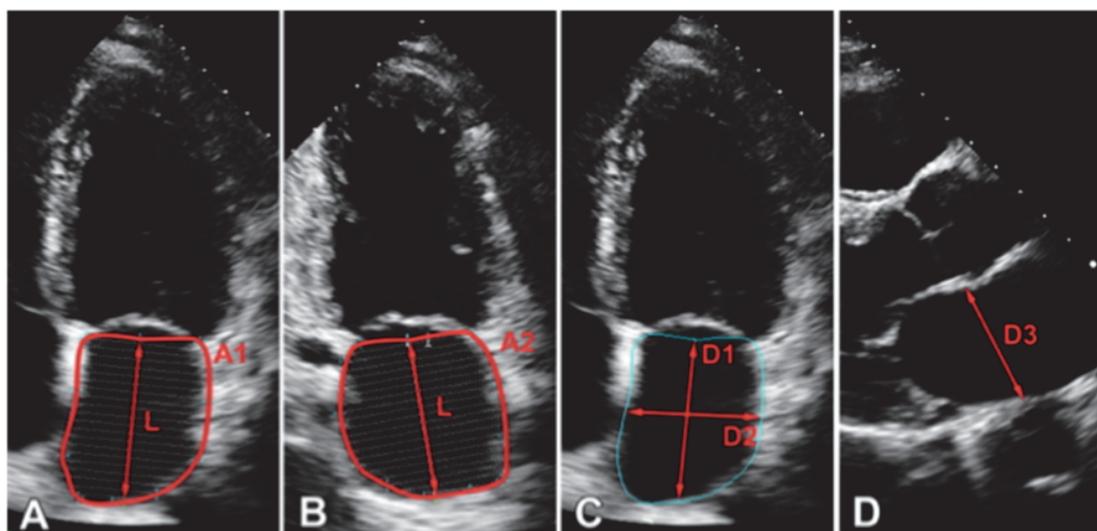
Left atrial chamber quantification using the area-length method and biplane modified Simpson's rule (A and B). A1 and A2. represent areas acquired in apical long-axis views consisting of a stack of 20 disks for Simpson's rule, while L is the atrial length measured from the middle of the mitral annular plane to the back wall. For the prolate ellipse method (C and D), D1 is measured from the middle of the plane of the mitral annulus to the superior aspect of the LA in a four-chamber view, while D2 is the orthogonal short-dimension to D1. D3 represents the anterior-posterior diameter measured in a parasternal long-axis.
